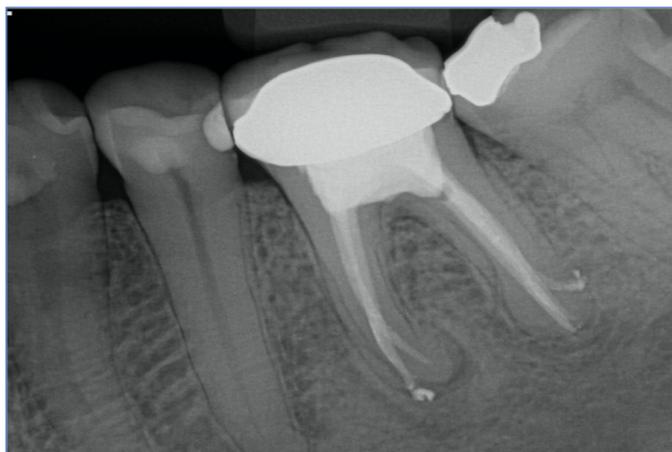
A 12-months follow-up PA radiograph shows that the peri-radicular radiolucency present around the distal root is completely healed with intact lamina dura and normal PDL space.
